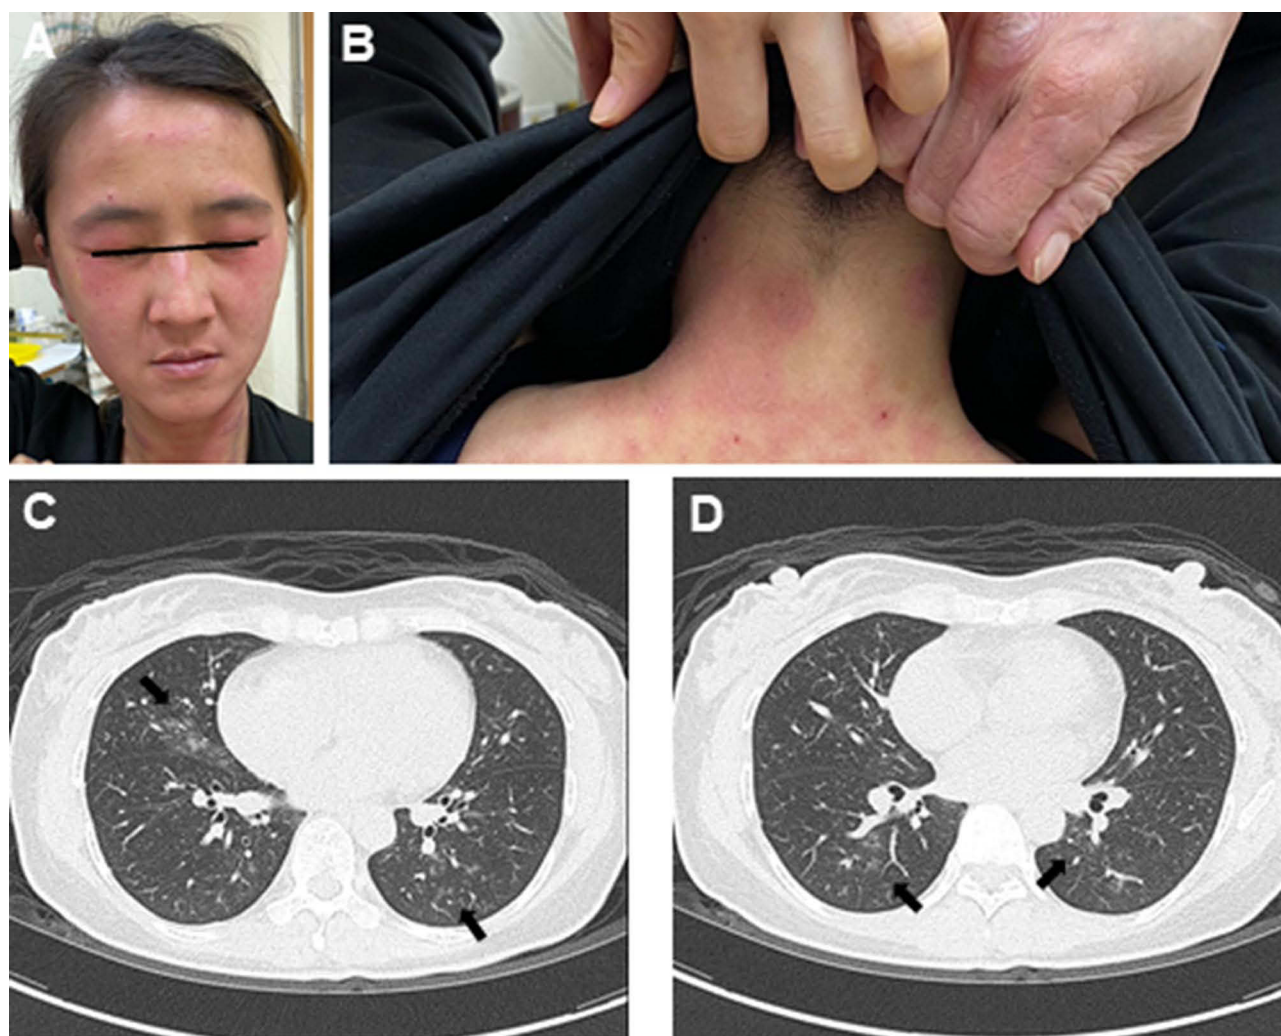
Skin photographs and chest images from an anti-MDA5-positive ADM patient with early-stage ILD before extended-release Tof treatment. Reddish-purple discoloration around the eyelids with swelling (heliotrope rash) (A) and erythematous area on the upper back and posterior neck (shawl sign) (B). Bilateral diffuse infiltration with ground-glass opacity (GGO) on high-resolution chest CT (C and D) at the diagnosis of ILD. Arrows indicate the GGO infiltration.
